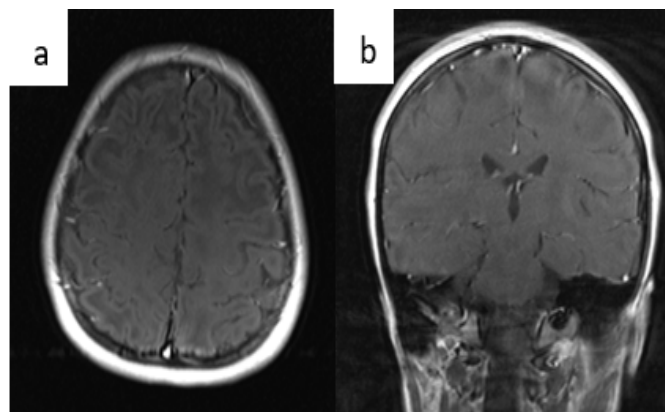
13years old girl Axial (a) and Coronal (b) MR imaging after contrast administration: Axial (a) and Coronal (b) T1 Fat-Sat + C MR enhancement was not observed in subcortical white matter lesions
